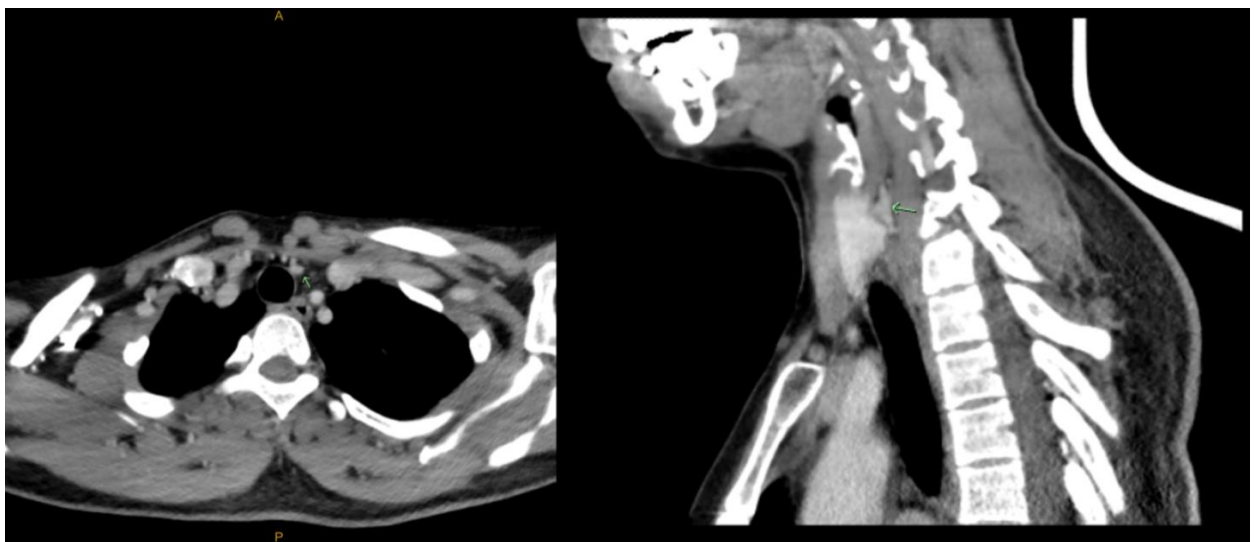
2015 4D computed tomography neck demonstrating 2x parathyroid adenomas
